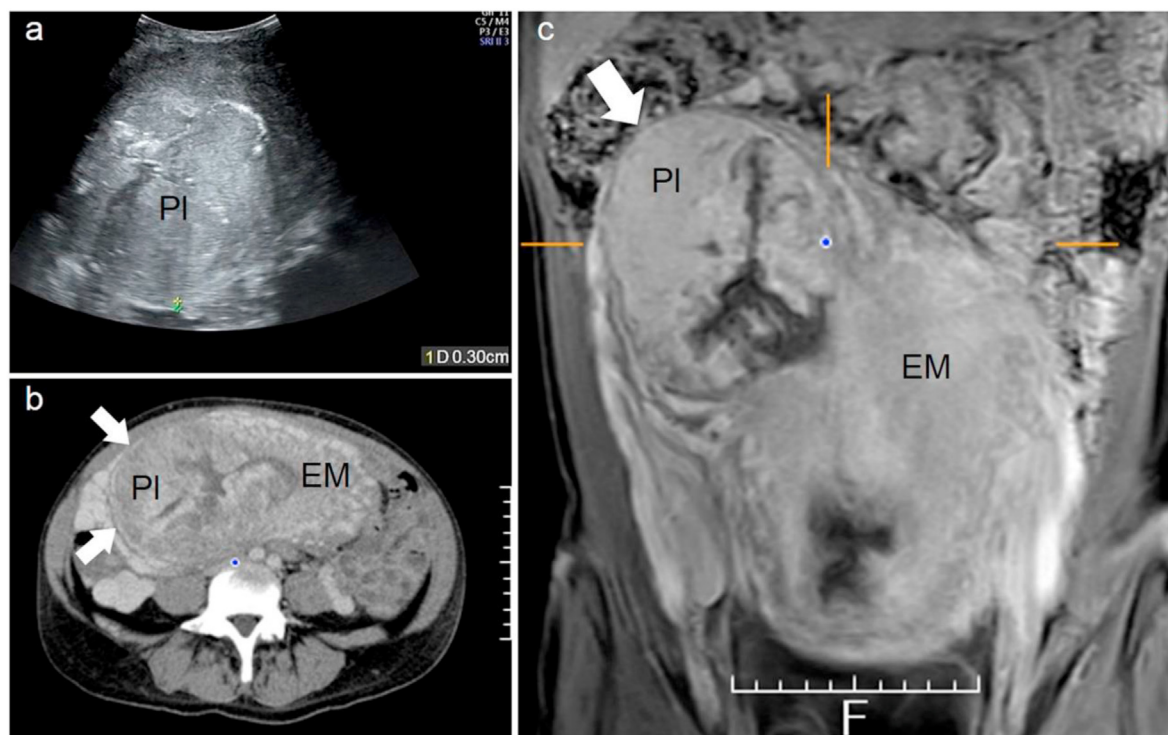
Postpartum images of Case 1. a) Transabdominal ultrasound image of the uterine fundus after a vaginal delivery of the fetus. The myometrium is only 3 mm thick (arrow). b) Axial contrast-enhanced CT image on PPD 2. Note the strong placenta enhancement and the thickness of the lateral myometrium around the placenta (arrow). c) Coronal gadolinium-enhanced T1-weighted MRI image on PPD 9, showing the placenta at the right uterine angle. Arrow showing thin myometrium. PPD, postoperative day; PI, placenta; EM, endometrium.
